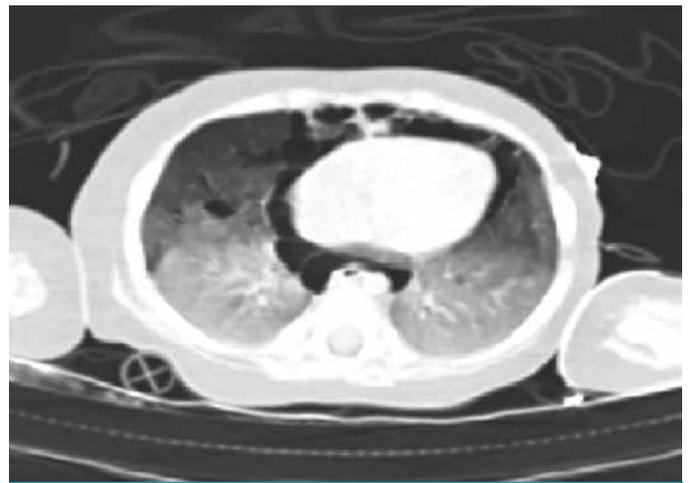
Chest CT scan of the patient
